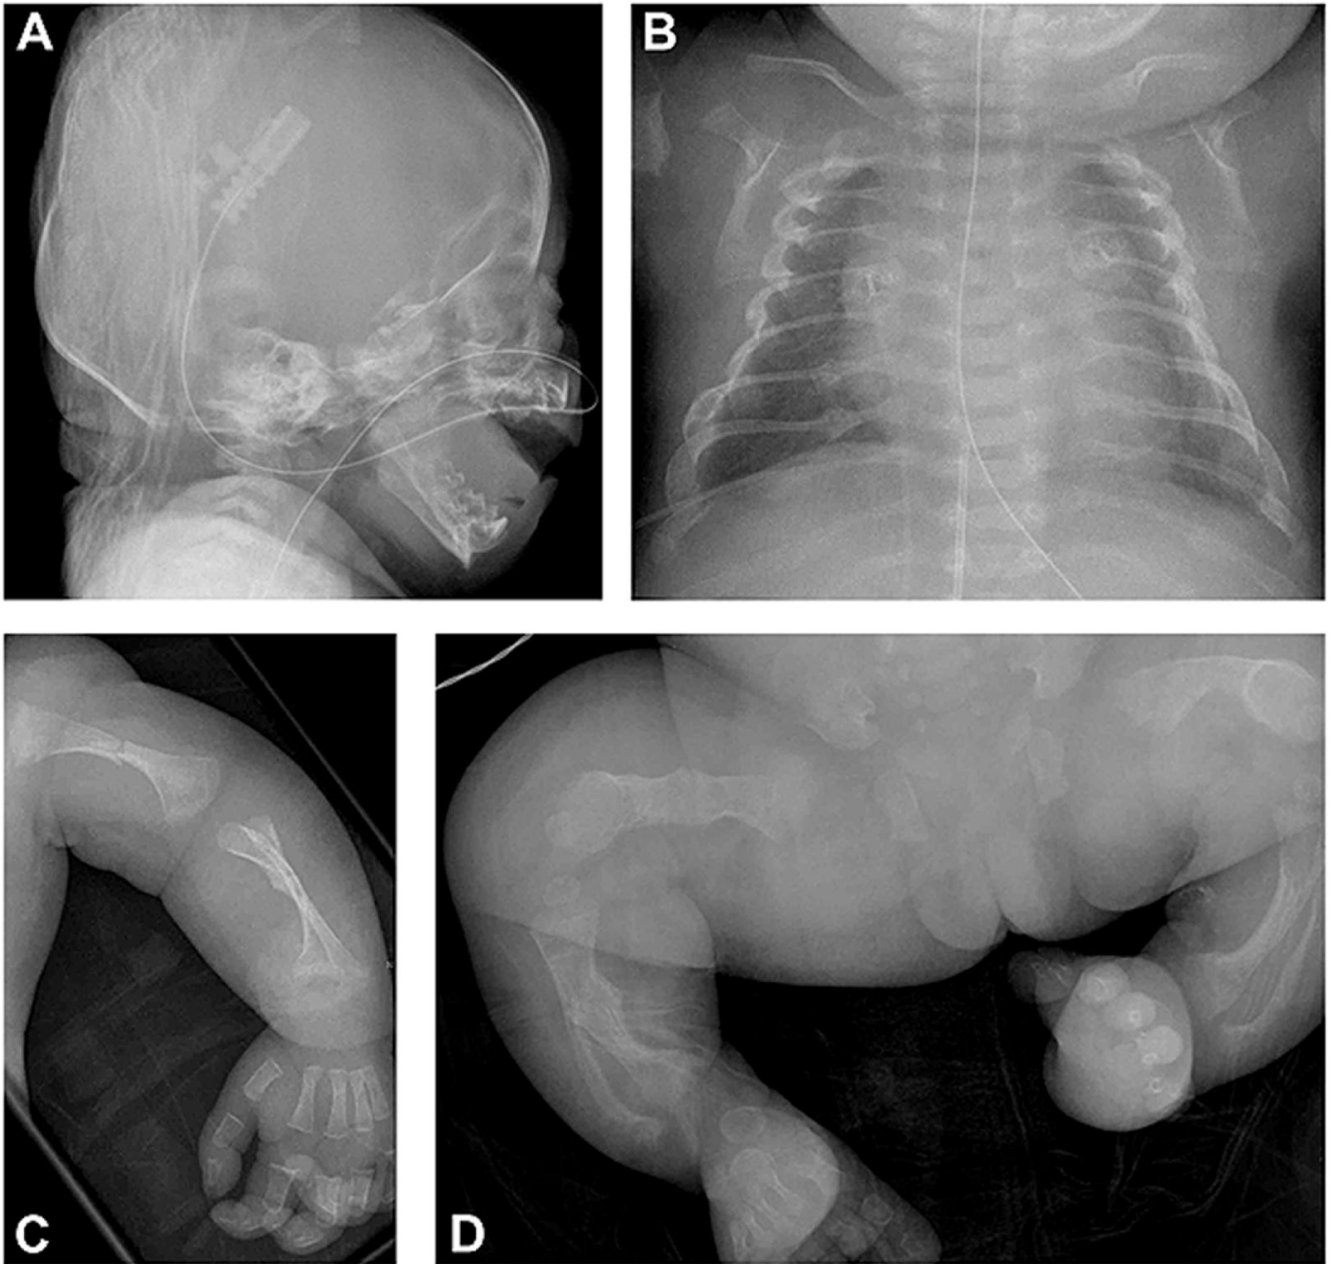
Early radiographs of Proband 2 with *CRTAP* mutation. A, B, C, and D, radiographs at age one day, consistent with severe OI. This infant was a compound heterozygote for mutations in *CRTAP* (c.278_293dup; c.822_826delAATACinsT).
